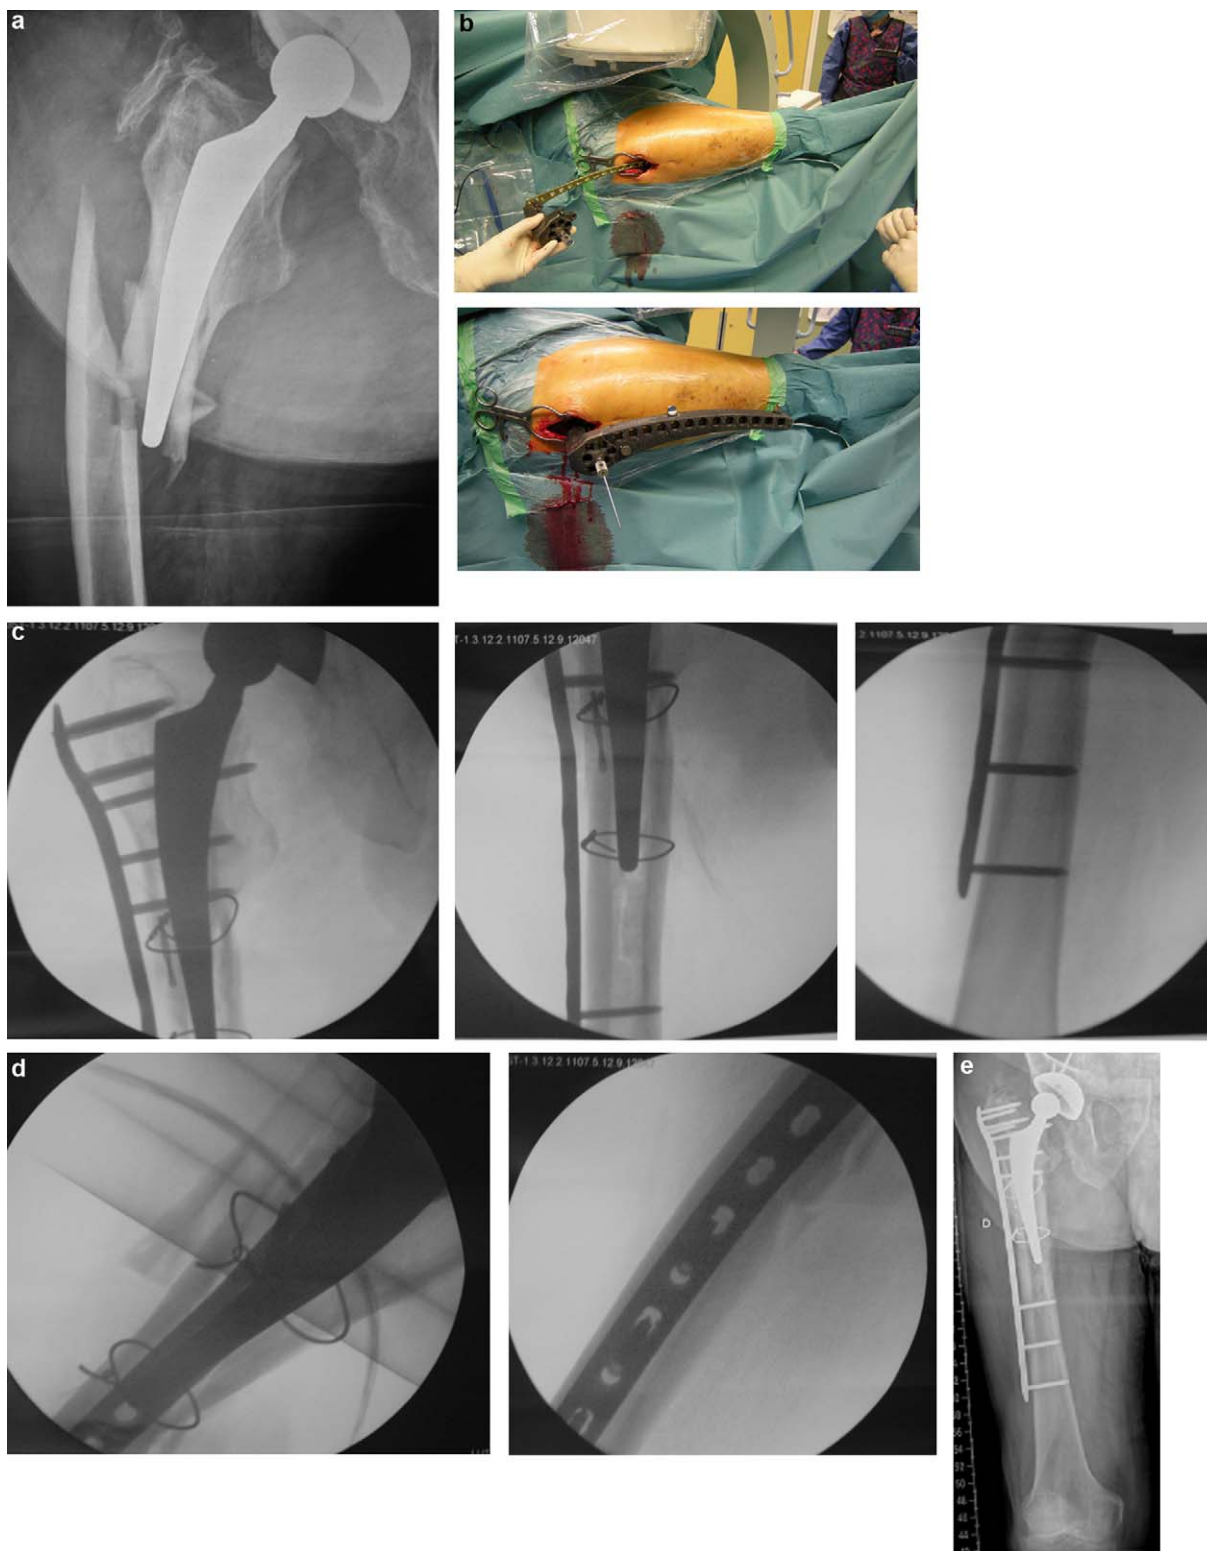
Application in type B1 fracture (Vancouver classification). (a) Preoperative AP X-ray, type B1 fracture. (b) Operative view of minimally invasive proximal approach. Use of LISS™ ancillary to facilitate plate introduction and locked screwing. Proximal K-wire enables control of plate level. (c) Final peroperative AP views. The "racket" of the distal femoral plate enables multiple (five locking screws) proximal fixation to the greater trochanter; the next three, more distal, screws are bicortical, to reinforce osteosynthesis. The screws introduced under the femoral shaft are spaced out to distribute and absorb stress. Traction and plate introduction were insufficient to obtain satisfactory reduction, and cerclage had to be performed on a limited approach to complete reduction before implanting the plate. (d) Final peroperative lateral views showing reduction and good alignment, particularly of the proximal "racket". (e) X-ray at 3 months' FU. Fracture consolidated; axis conserved; no secondary displacement.
